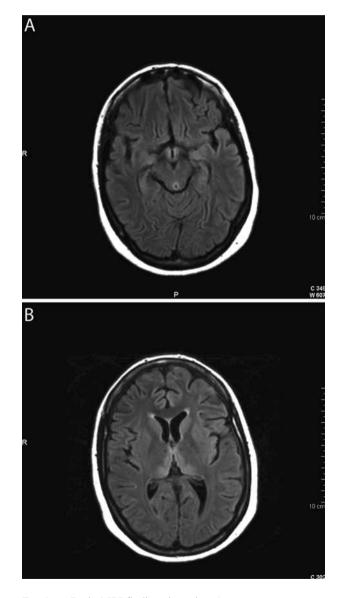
Brain MRI findings in patient 1
